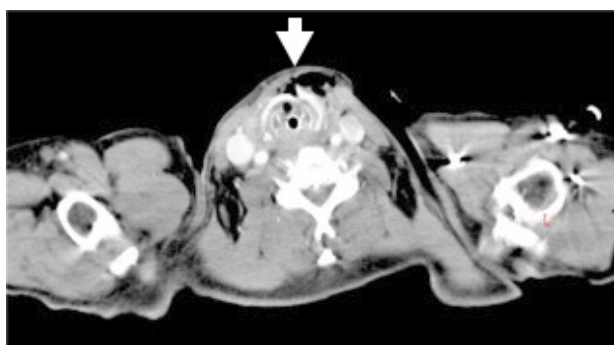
Contrast enhanced CT scan showing cricoid cartilage fracture, swollen laryngeal mucosa surrounding the endotracheal tube, and subcutaneous emphysema (white arrow).
